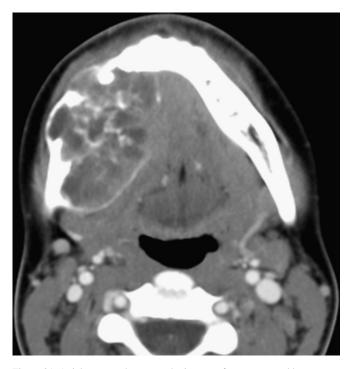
Axial computed tomography images of an aneurysmal bone cysts, involving the mandible, note the multiple cystic regions and gross expansion of the mandible. A few small fluid levels are evident.
